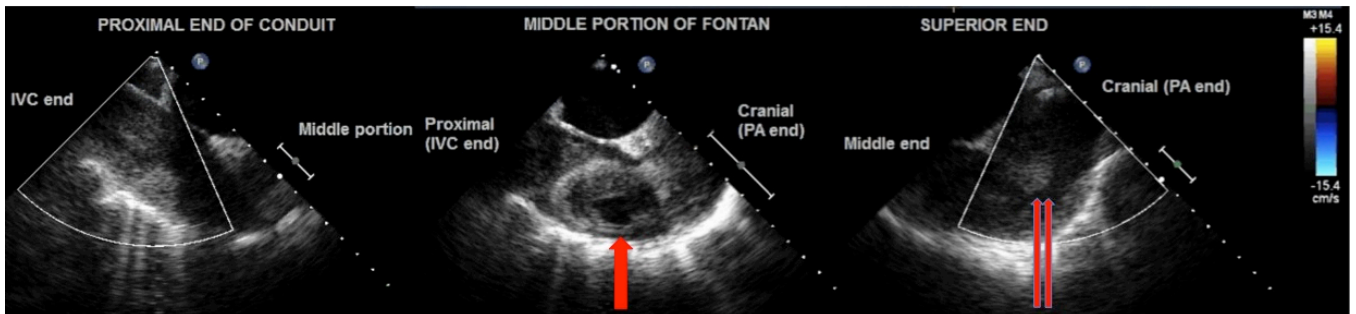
Transesophageal echocardiography showing extensive thrombosis and stasis throughout the Fontan conduit, with acute thrombosis with mobile elements (double red arrows) and large chronic thrombosis with central necrosis and liquefaction (red arrow).
